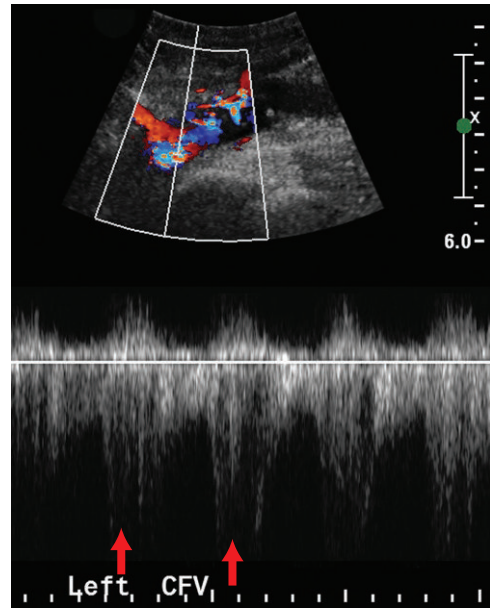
Color and spectral Doppler of the common femoral vein do not show the normal phasic variation. There is spectral broadening as well as forward and reverse flow. In addition there are periodic increases in the Doppler velocity (arrows) corresponding to systole. This is due to an inrush of arterial flow through the fistula in systole creating an “arterialized” venous waveform.
